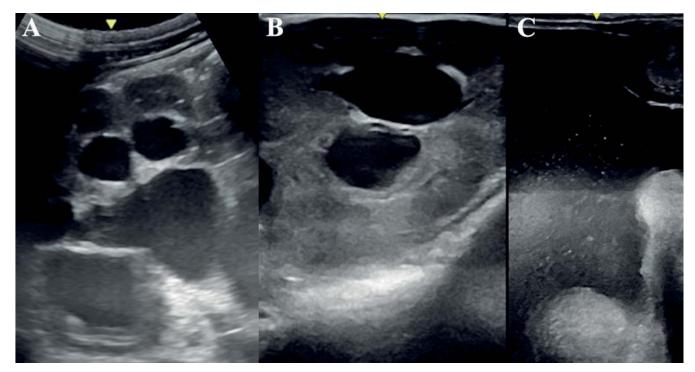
Rectal and percutaneous ultrasonographic images. Dilated calices in the right kidney (4.06 cm of maximal length) (A). Dilated calices in the caudal pole of the left kidney (1.82 cm of maximal length) (B). The pregnant uterus at the entrance to the pelvic cavity (C).
